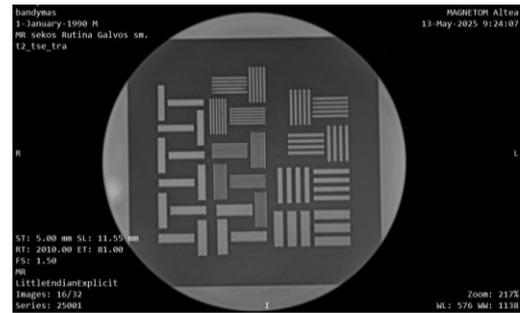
MRI images showing degradation in low-contrast detectability – blurring of fine anatomical details, particularly at the edges of structures [9]
